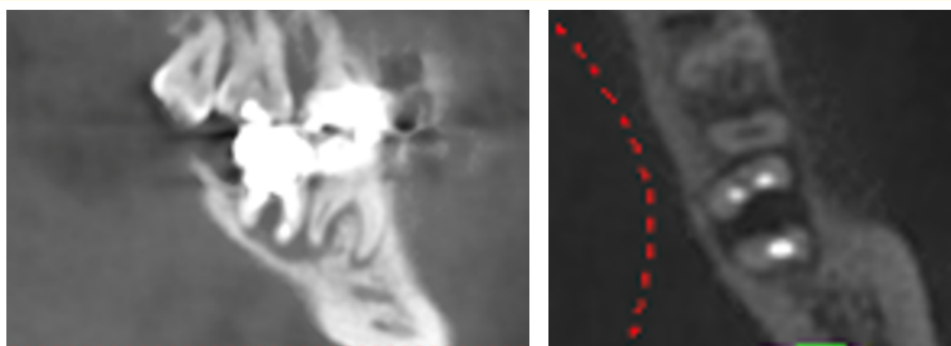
CBCT images of teeth #36 and 37 before the procedure
